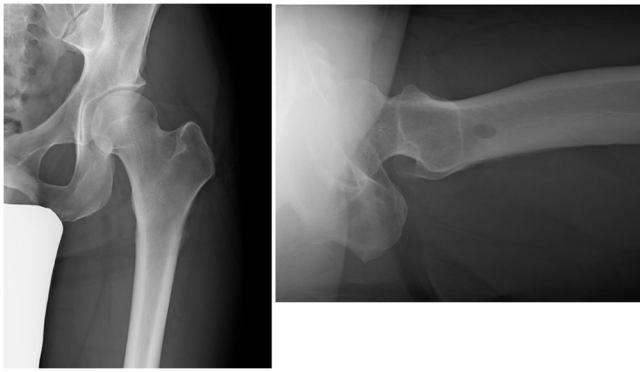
Plain radiographs of the left femur on admission.
